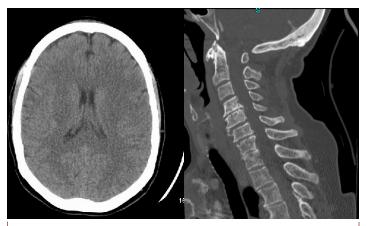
Normal non-contrast head and cervical spine CT
